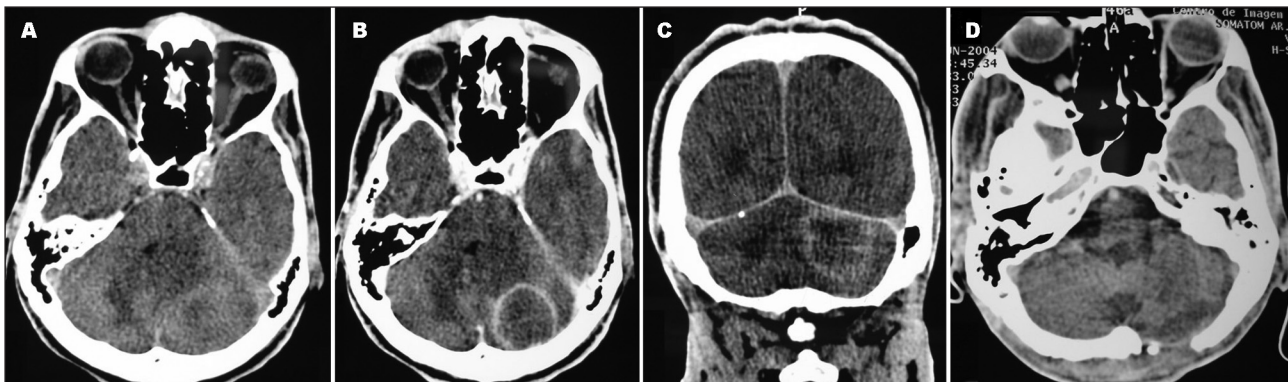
Head CT scans showed a contrast-enhanced mass effect lesion on the left cerebellar hemisphere superiorly limited by the tentorium and remembering a metastatic neoplasm [A, B and C]. Complete resection of the lesion by a suboccipital craniectomy is shown in Fig 1D.
